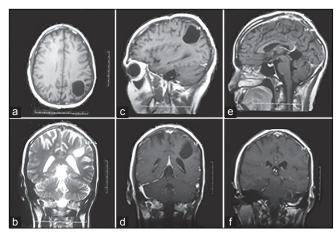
MRI brain plain (a and b) and contrast (c-f) showing cystic space corresponding to the removed tumour. No residual tumour identified. Note the ex-vacuo dilatation of the corresponding lateral ventricle (b and d). Hypothalamic region is not showing any identifiable abnormality
